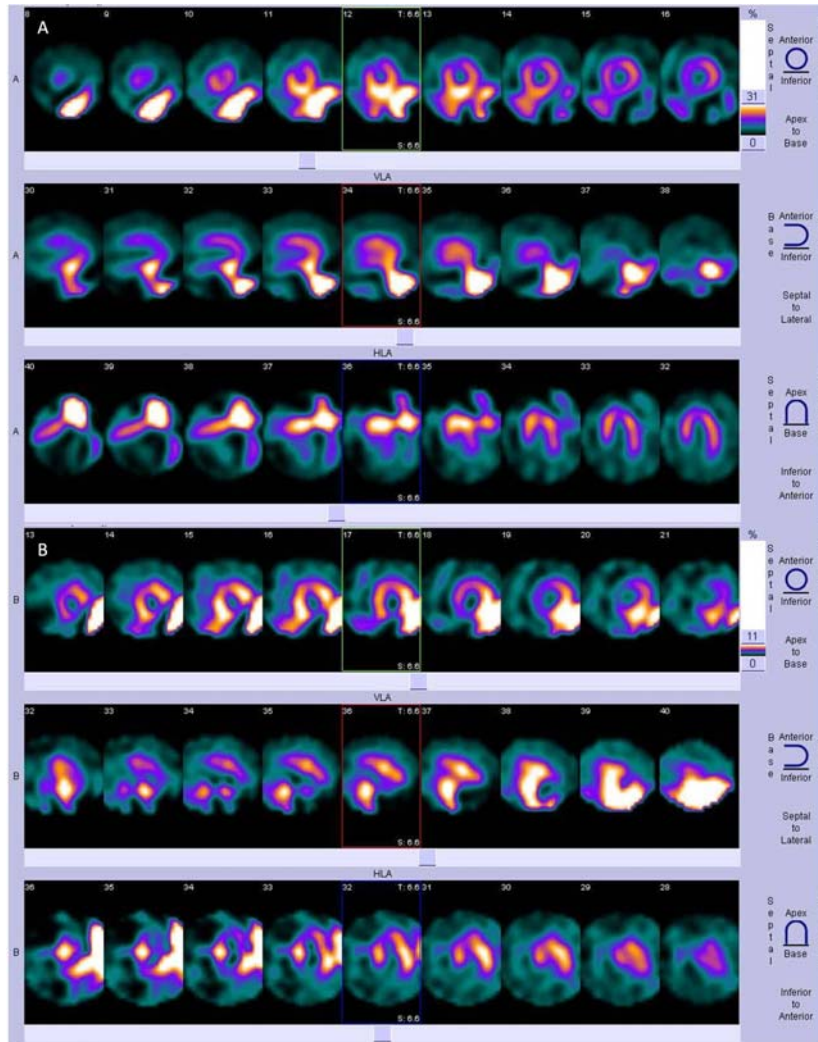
Processed images of 3 (A) and 4 (B) hour SPECT of the patient.
